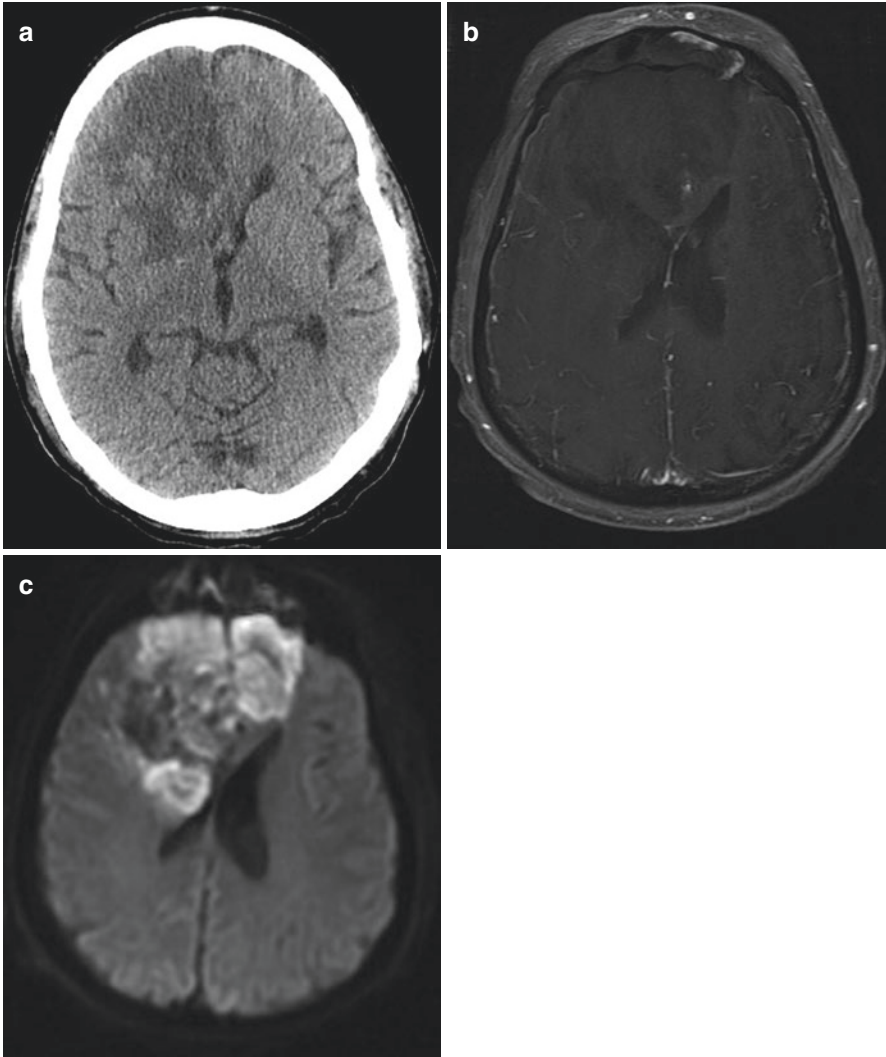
Chronic lymphocytic leukemia patient with known sinonasal infection presents with increasing confusion, and noncontrast head CT reveals a large bilateral frontal lobe cortical-based area of hypoattenuation (a) presumed to represent cerebritis. Further imaging was done with contrast-enhanced brain MR, which confirmed findings of cerebritis with nonenhancing areas of edema (b), and restricted diffusion (c)
